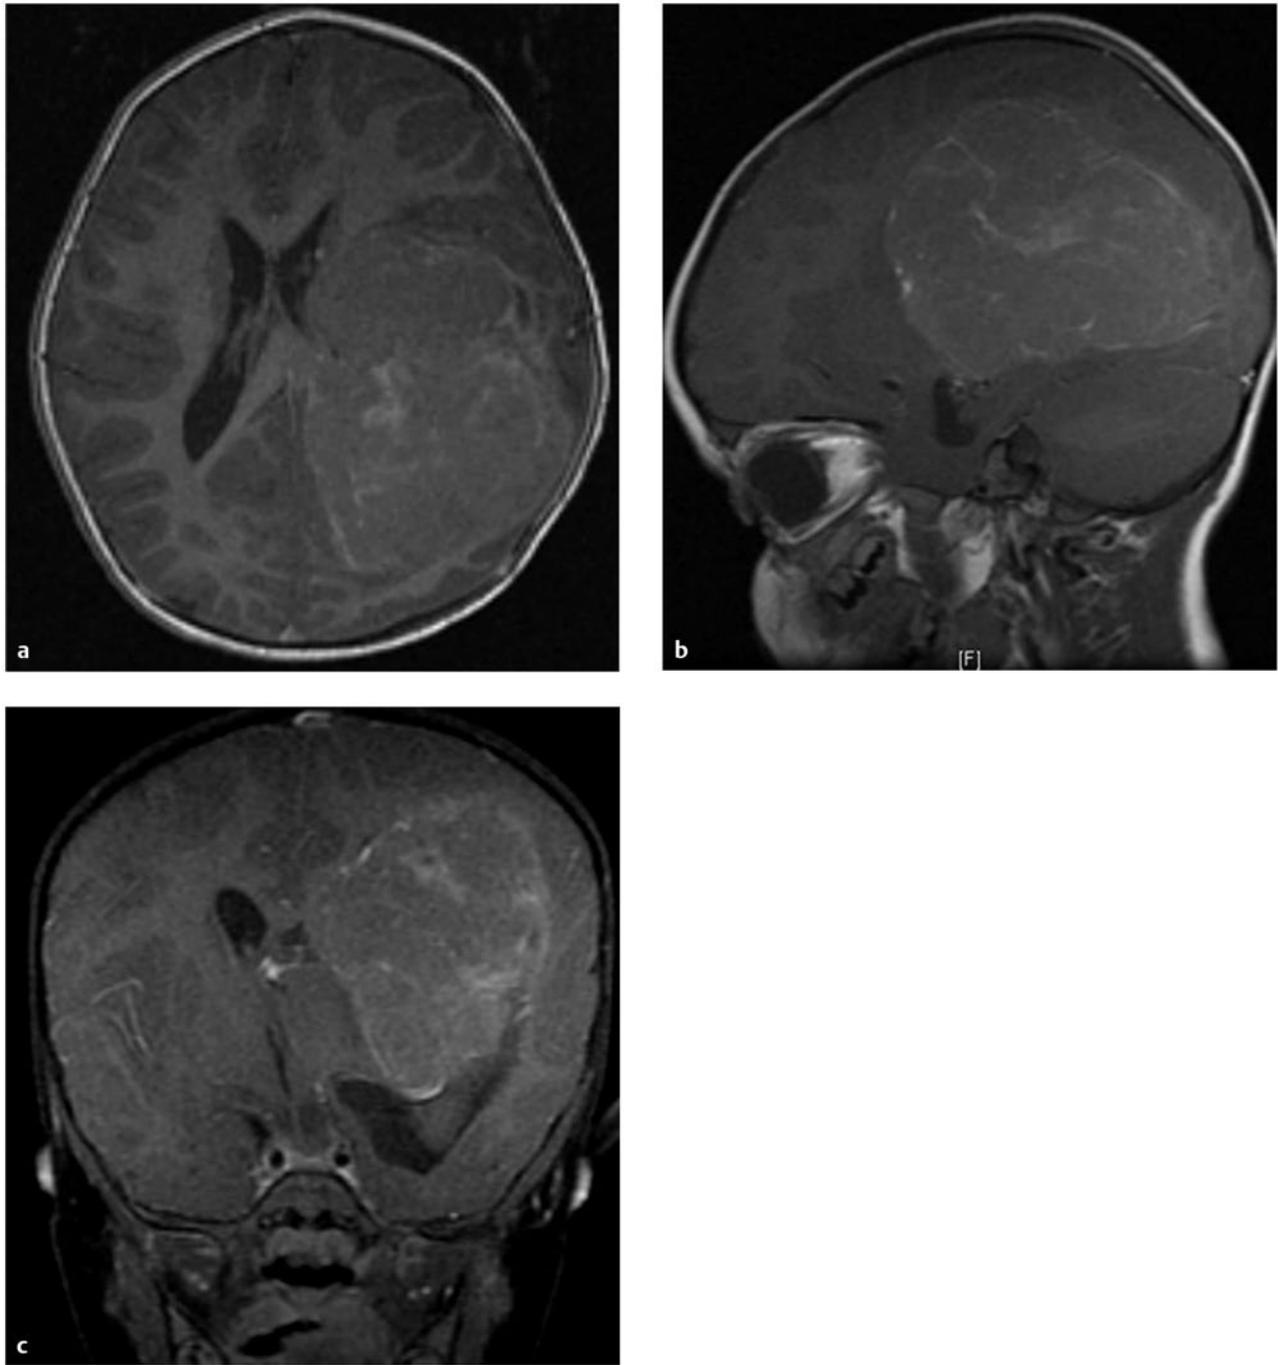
Axial (a), sagittal (b), and coronal (c) gadolinium-enhanced T1 magnetic resonance images of a 4-year-old girl who presented with progressive hemiparesis. This choroid plexus carcinoma (CPC) was resected. The tumor is located within the ventricle, centered in the atrium, and has a variable enhancement pattern that is often suggestive of a CPC.
